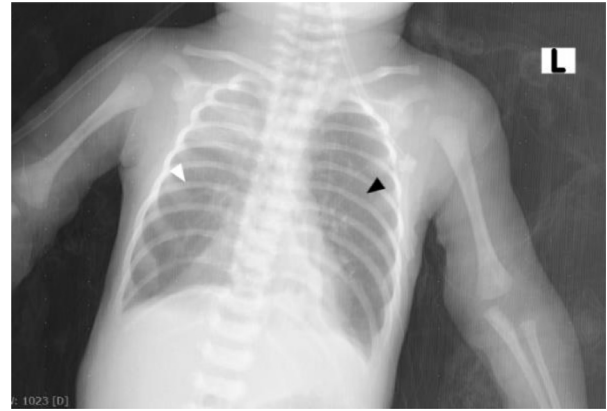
Supine chest X-ray shows hyperlucency of the right middle lung (white arrowhead) as well as the majority of the left lung (black arrowhead). Right upper lung as well as bilateral medial lower lobe sharply marginated opacities are also seen.
